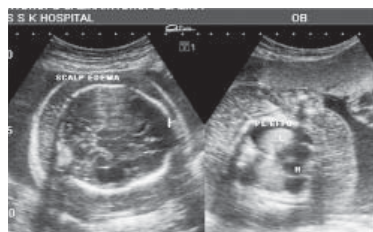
Ultrasound image of hydrops fetalis
